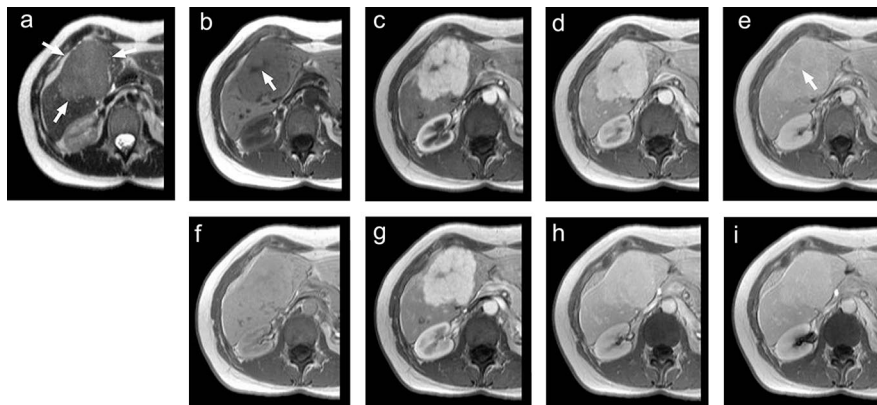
Typical FNH in a 34-year-old female patient. A large lesion (arrow) in liver segments IV and V is clearly seen as hyperintense against the surrounding liver parenchyma on the unenhanced T2-weighted image (a) and as hypointense on the unenhanced T1-weighted image (b). A hypointense central scar (arrow) within the lesion in (b) is suggestive of FNH. During the arterial phase at 25 seconds after the first injection of 0.05 mmol/kg gadobenate dimeglumine (c), the lesion appears as strongly hyperintense with a hypointense central scar. Contrast agent pooling during the portal-venous phase at 60 seconds (d) and the equilibrium phase at 5 minutes (e) after injection, combined with enhancement of the central scar (arrow in e) in the equilibrium phase, is highly suggestive of FNH. During the delayed phase (f) at 60 minutes after the injection of gadobenate dimeglumine, the lesion appears isointense to the surrounding parenchyma while the central scar is very faintly hypointense. A second dynamic series (g, h, and i) acquired after a second injection of 0.05 mmol/kg gadobenate dimeglumine reveals similar enhancement behavior to that seen during the first dynamic series although the more strongly enhanced surrounding normal parenchyma during the portal-venous phase (h) results in lower lesion-to-liver contrast and earlier uptake of contrast into the central scar.
